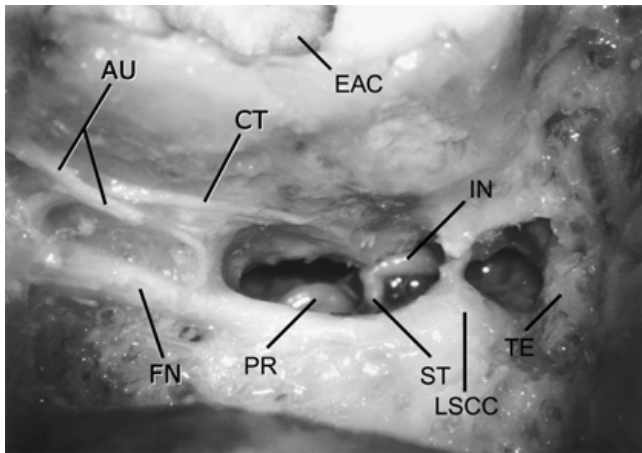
A temporal bone after dissection of facial recess. AU, auricular branch of facial nerve; CT, chorda tympani; EAC, external auditory canal; FN, facial nerve; IN, incus; LSCC, lateral semicircular canal; PR, promontory; ST, stapes; TE, tegmen.
